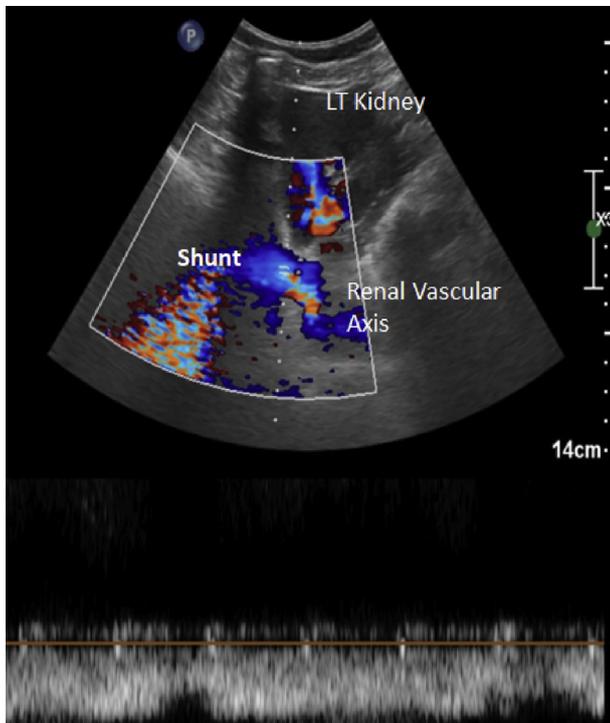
Doppler ultrasound upper abdomen.
